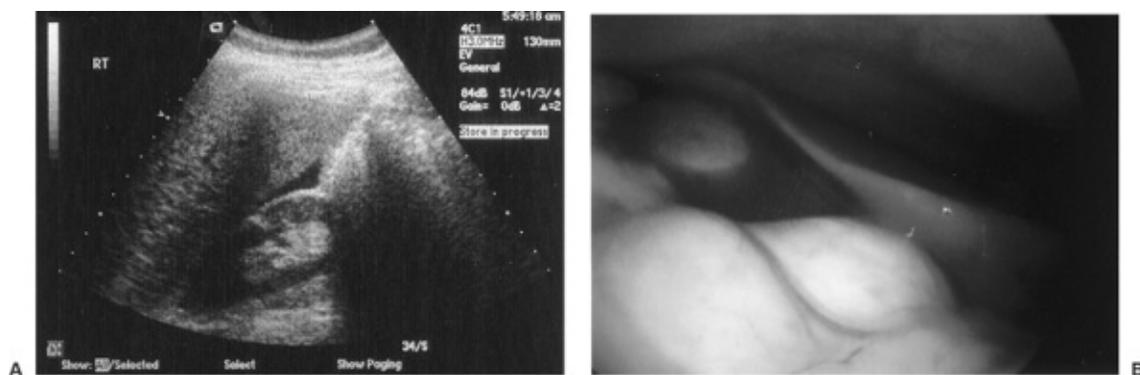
Ultrasonogram of free fluid noted under the liver edge above the right kidney. Confirmed to be blood from a ruptured ectopic pregnancy at the time of surgery. (Courtesy of R. Mangal, M.D., Obstetrics/Gynecologic Associates, Houston, TX.)
